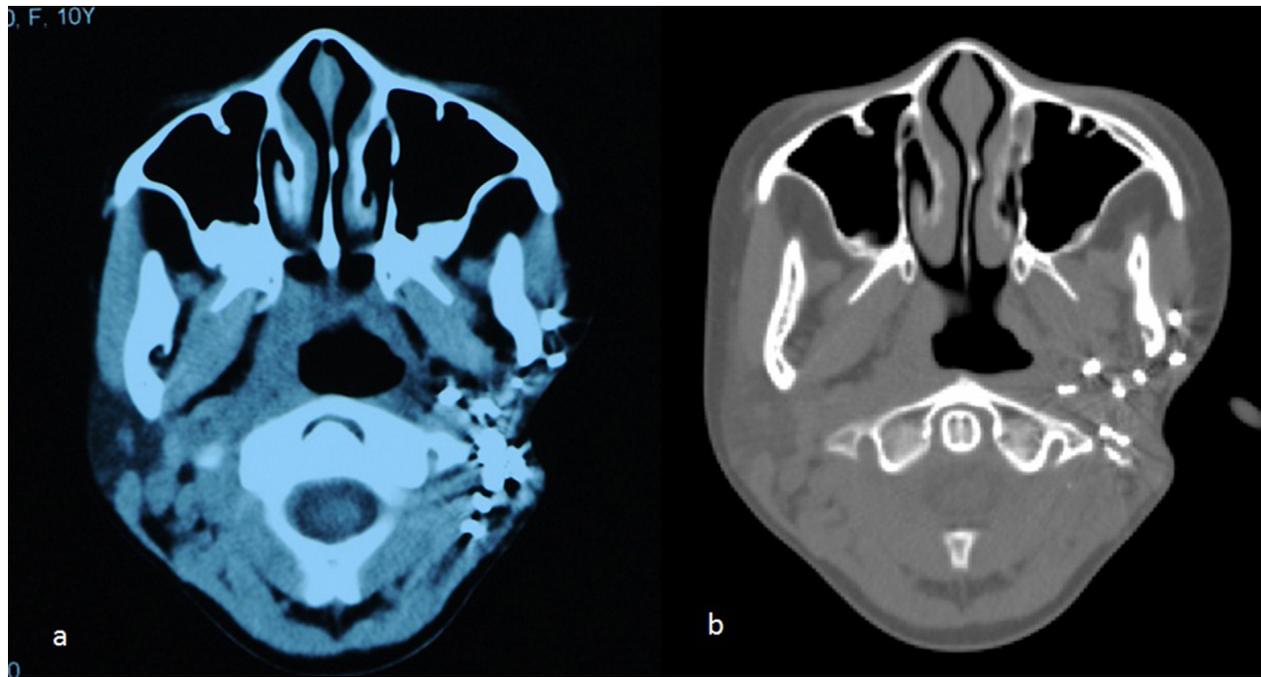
CT scans showing no tumour recurrence at 3 years (a) and 6 years (b) after seed implantation.
